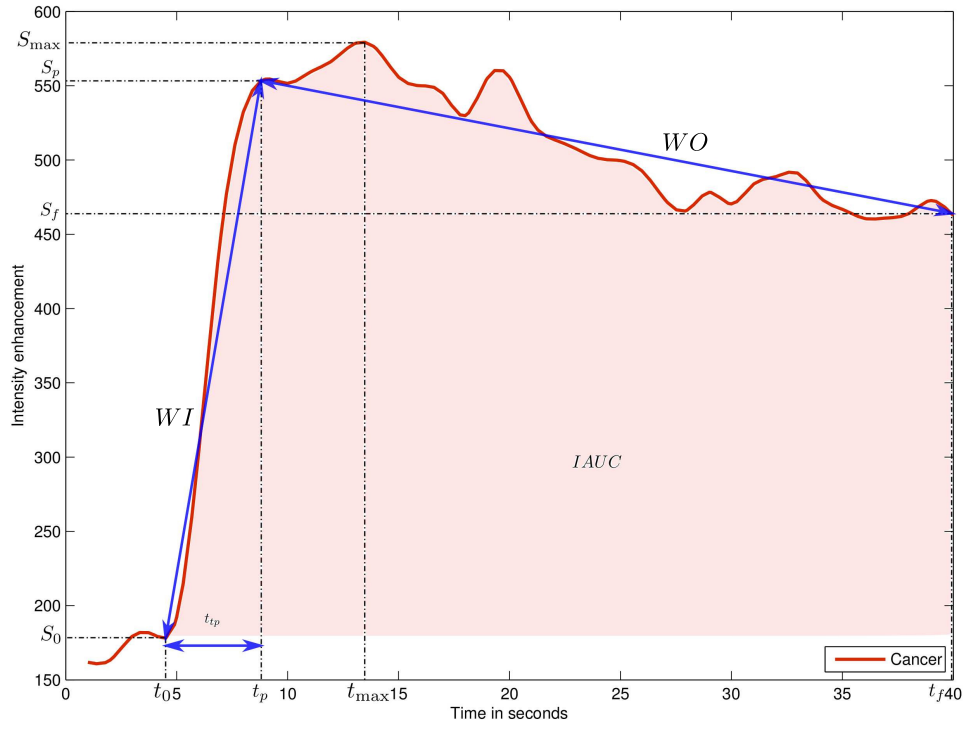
Graphical representation of the different semi-quantitative features used for DCE-MRI analysis.
